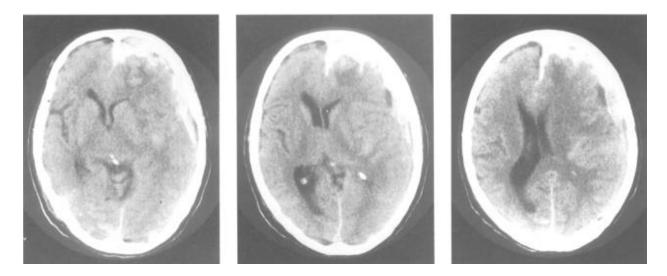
shows CT scans taken 34 hours after the injury. It reveals acute bleeding on the left side of the brain and a bruise on the front left part. There's a noticeable shift of the brain's central line towards the right side.
